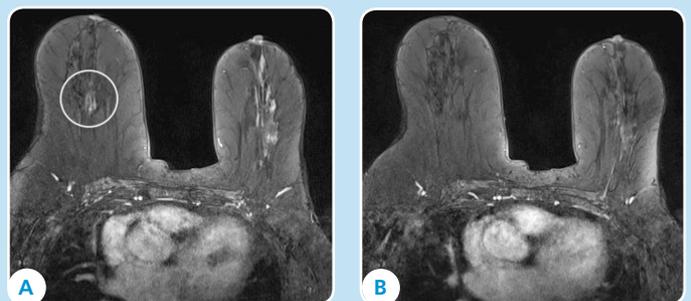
Contrast-enhanced T1 with fat saturation images showing the fully ablated lesion shown in Fig.1: A) MRI performed before treatment (white circle). B) MRI performed after 12 months showing no enhancement or suspicious feature
